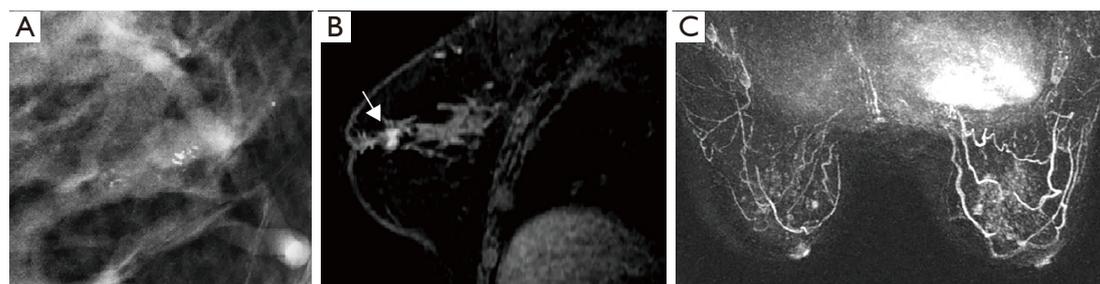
Female, 61 years old, found a mass in left breast for 1 month. (A) The magnified partial craniocaudal image of a left mammogram, showing line-like amorphous calcification in the posterior area of the left areola, BI-RADS 4A. (B) An MRI sagittal enhanced recombination image, showing the enhanced area in the left posterior areola area, basically consistent with the distribution range of calcification (†). (C) The MIP of MRI, showing moderate to marked BPE in the left breast and several small, enhanced masses in the medial part of the left posterior areola with linear distribution, BI-RADS 4B. The pathology of the core needle biopsy revealed an intraductal papillary tumor with high ductal epithelial hyperplasia, which was upgraded to a papillary lesion with middle-grade DCIS after surgery. BI-RADS, Breast Imaging Reporting and Data System; MRI, magnetic resonance imaging; MIP, maximal intensity projection; BPE, background parenchymal enhancement; DCIS, ductal carcinoma in situ.
